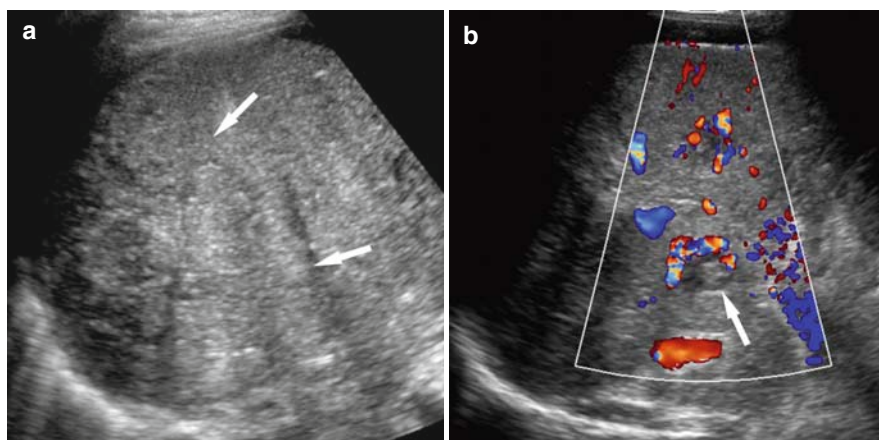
Infiltrative HCC with right portal vein thrombosis in a 51-year-old man with hepatitis C. (a) US image shows an ill-defined heterogeneous area (*arrows*) in the liver. (b) Color Doppler US image shows a thrombosis within the right portal vein containing pulsating flow representing tumor thrombosis.
